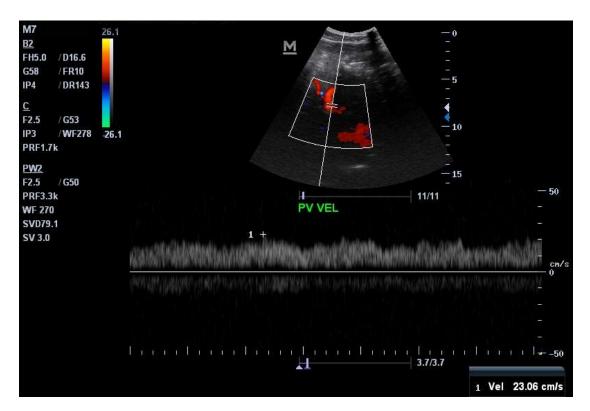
35 year old. Ultrasound demonstrates hyperechoic liver parenchyma with a normal portal vein velocity
